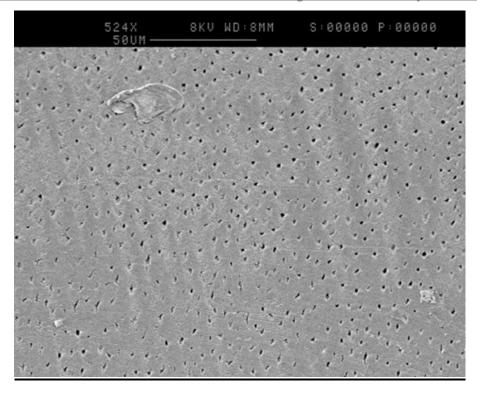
SEM image (500x magnification) to show Hülsmann score 1, in Group 4, treated by brushing and ultrasonication in distilled water.
